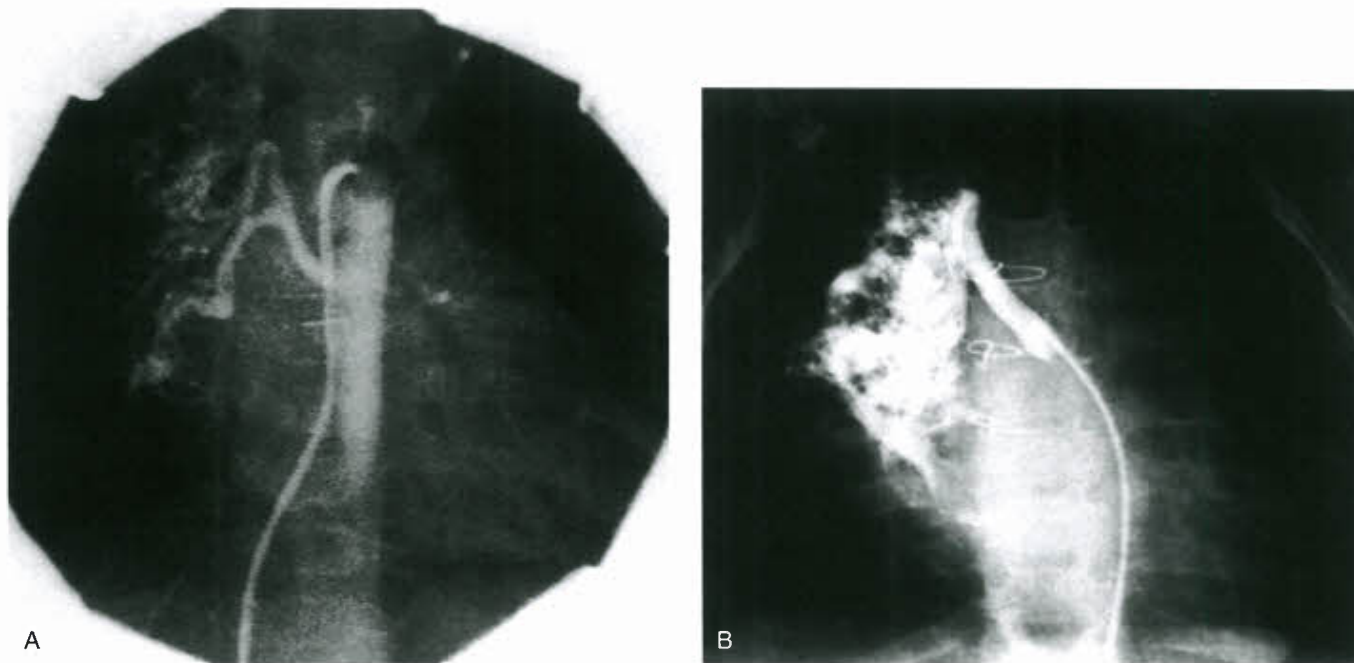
A: Preoperative transvenous descending aortogram in a neonate with TGA/IVS showing enlarged bronchial arteries (following the right main stem bronchus) to the right lung. B: Same patient 42 years after a primary arterial switch; a selective injection in the same bronchial artery shows a markedly enlarged vessel, with prompt visualization of the pulmonary veins and left atrium on levophase. At the postoperative catheterization, the left ventricular end-diastolic pressure was elevated at 18 mm Hg, and M-mode echocardiographic measurements of left ventricular end-diastolic dimension were increased, suggesting a significant volume overload. Following successful coil embolization, the left ventricular end-diastolic pressure fell to 7 mm Hg, and the echocardiographic indices normalized.
